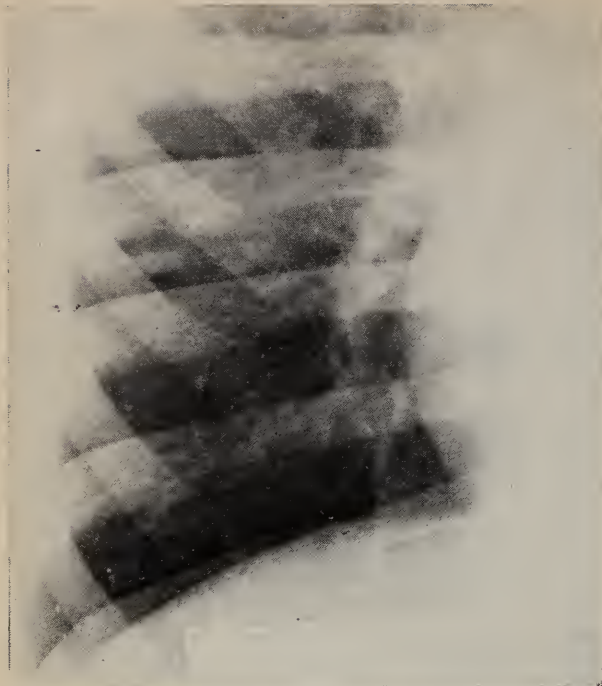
Detailed x-ray view of the right lower lobe of a young girl taken 25 May 1959. A small but definite infiltration is present (compare with Figure 3).
